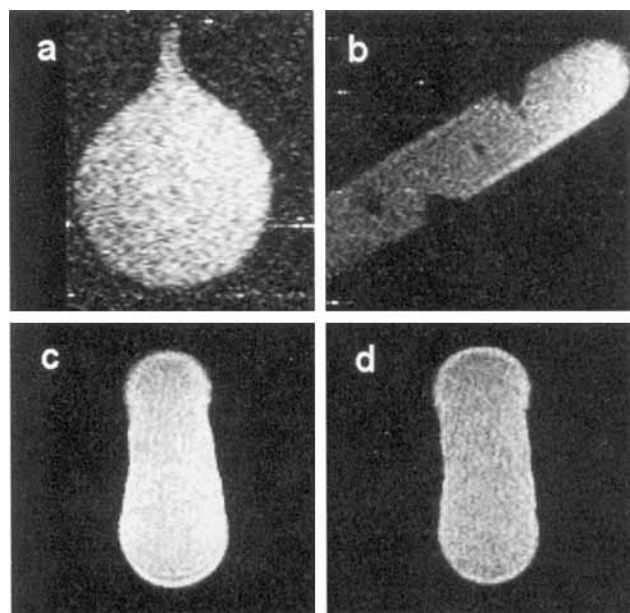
^3He FLASH MR imaging at $B_0 = 0.8$ T (25.9 MHz Larmor frequency) of various glass cells ($V \approx 100$ – 300 cm³) filled with hyperpolarized ^3He gas. The irregular shape of cell wall in (b) is clearly depicted. Experimental parameters: (a) 2D FLASH, $TR = 150$ ms, $TE = 5$ ms, $FOV = 180 \times 180$ mm², matrix 128×256 , $N = 1$; (b) 2D FLASH, $TR = 225$ ms, $TE = 5$ ms, $FOV = 230 \times 230$ mm², matrix 192×256 , $N = 1$; (c, d) 3D FLASH, $TR = 22$ ms, $TE = 6$ ms, $FOV = 250 \times 250$ mm², matrix 256×256 , $N = 1$, 96 mm slab, and 32 partitions resulting in 3 mm slice thickness.
